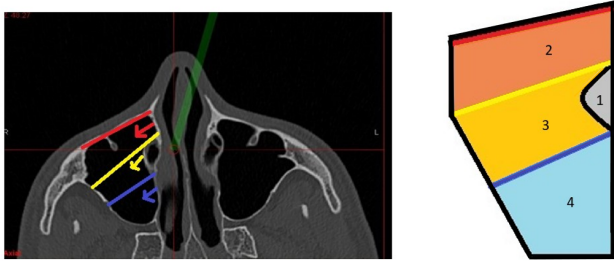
Comparative assessment: visual scope and pathological control efficacy of ENLWD, PLFA and PLWA. A) CT scan, B) Axial visualization of the maxillary sinus and respective approaches in a picturized figure. Legend: The lines without arrow represent: 1 – Nasolacrimal Duct, 2 – PLWA in red, 3 – PLFA in yellow, 4 – ELNWD in blue. The lines with arrows in respective colors represent the area that each technique can offer in terms of visualization of the maxillary sinus and control of pathology (2,3,4).
